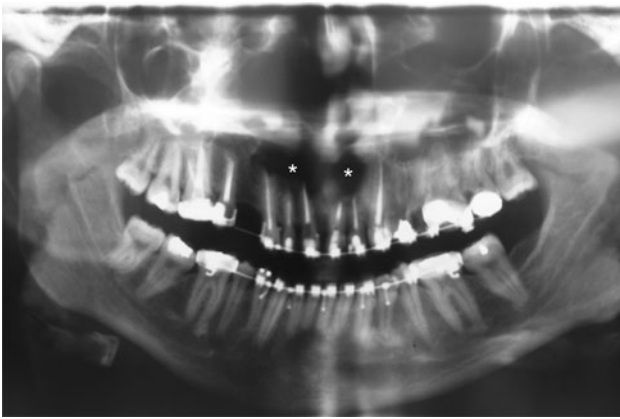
Radiographically, ABC presents as a radiolucent image and with well-defined margins. Lesion located *above* the apices of the maxillary anterior teeth from the region of 13–22. There are external root resorption at the apex of 11, 12, 21 and 22
